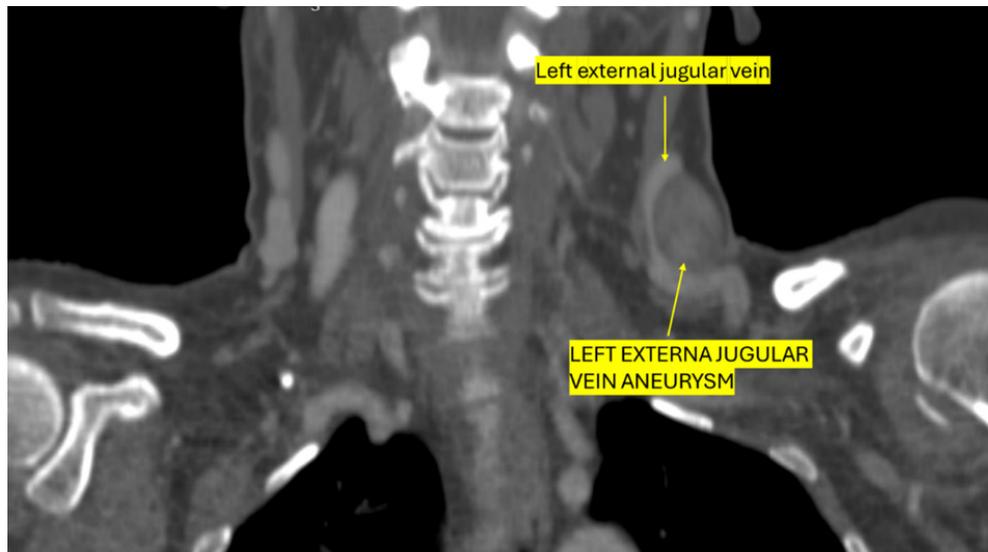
CT angiography showing a saccular aneurysm arising from the left external jugular vein (coronal).
